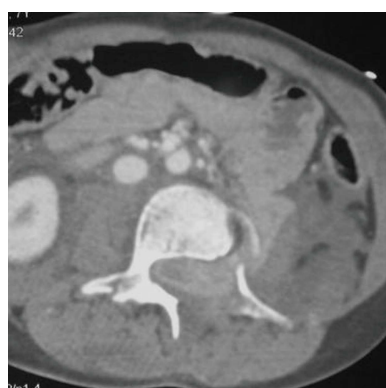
Initial axial computed tomographic scan showing entrapment of small bowel loop in the spinal canal. No air was seen in the spinal canal.
